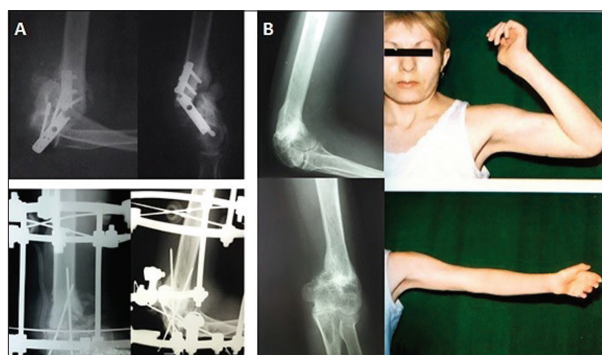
(A) Radiographs of a 33-year-old female patient treated with the Ilizarov method eight months after failed initial osteosynthesis; (B) radiographs and clinical photographs after the application of the Ilizarov fixator for nine months, showing complete union, with elbow motion restoration
